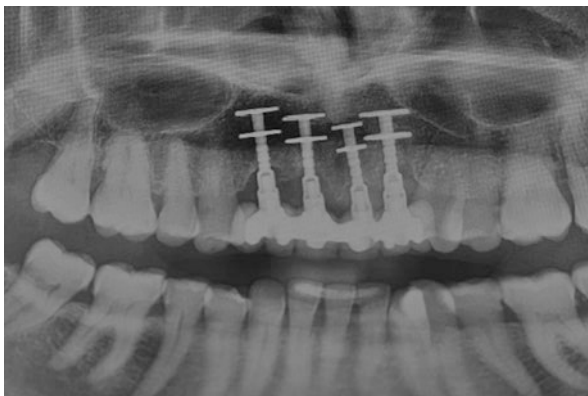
D3 bone in the anterior maxilla. Severe facial trauma resulted in loss of the six upper front teeth along with their anterior buccal plate, leaving a high knife bone ridge. Four double-disk Diskimplants® were placed in 1985. The panoramic radiograph taken in 2016 shows these implants that are still in service after 31 years with no signs of peri-implantitis. A bone gain is visible in many areas
